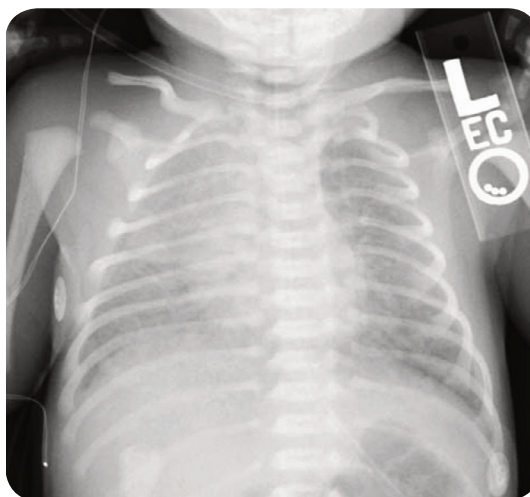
A plain chest radiograph of a neonate demonstrating bilateral, diffuse, coarse opacities secondary to meconium aspiration.
